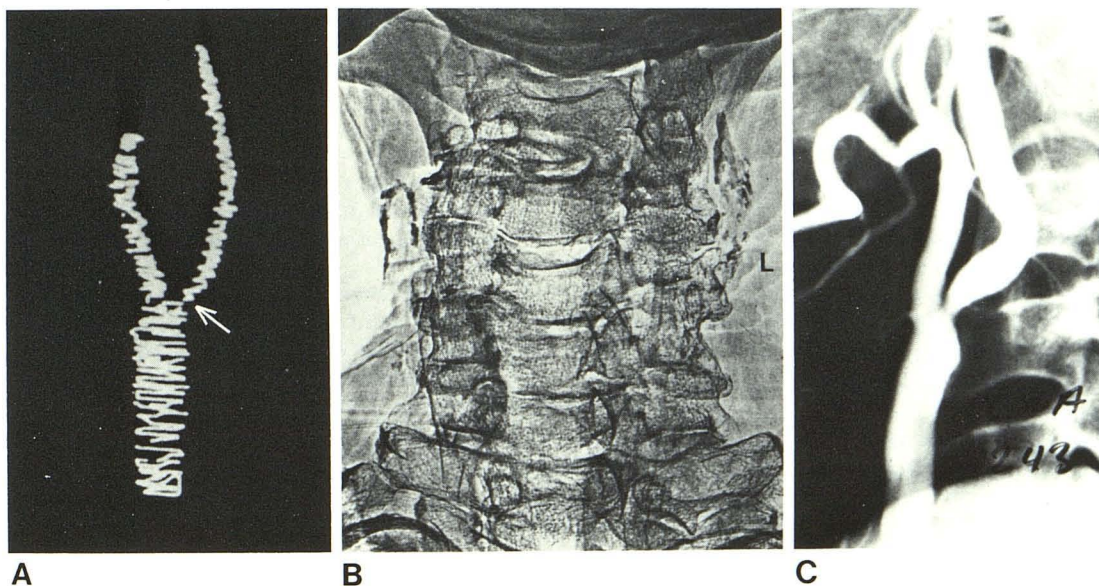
Obscured signals. False-negative diagnosis of stenosis due to calcified plaque in 65-year-old man with peripheral vascular disease and bilateral cervical bruits. A, Doppler examination on left demonstrated nonsounding area (arrow) in proximal internal carotid. Severe turbulent flow was evident distal to this and posterior orbital flow was reversed on left. B, Neck xerogram. Extensive calcification at left carotid bifurcation was believed to account for absence of Doppler signals and failure to detect an abnormal Doppler frequency shift. C, Arteriogram. Major stenosis in zone of dense calcification.
